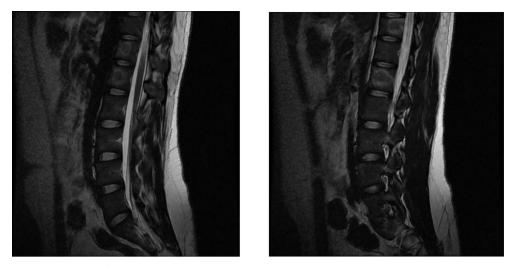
MRI spine showing altered signal intensities in multiple vertebrae.
